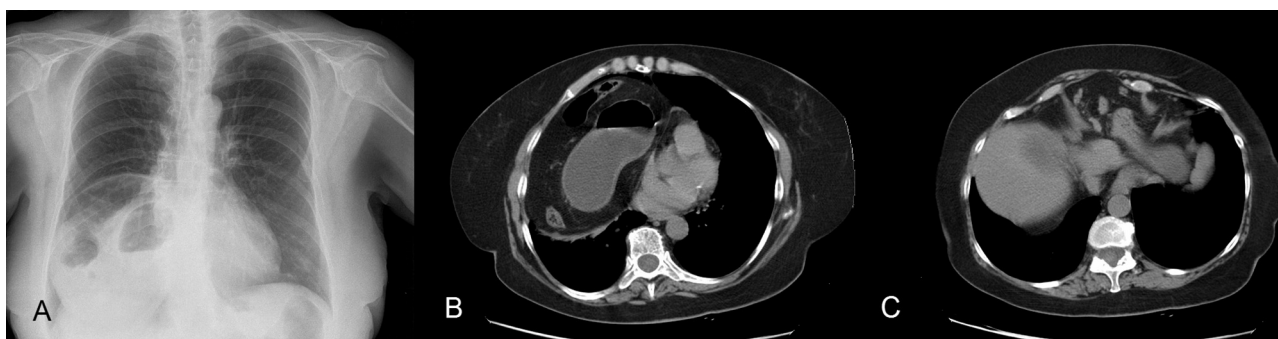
Preoperative radiology findings. (A) Chest radiograph depicting a large diaphragmatic hernia located in the right hemithorax. (B) Views of CT scan showing contents of the hernia sac and (C) point of herniation in the anterior part of the diaphragm.
